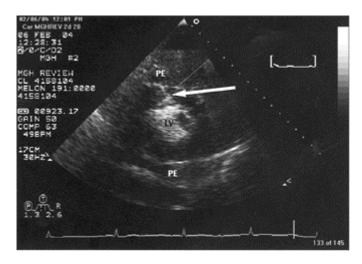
Ventricular free-wall rupture. Short-axis parasternal view of the left ventricle of an elderly woman with history of diabetes and hypertension who presented with hypotension and acute myocardial infarction after 3 days of chest pain at home. Pericardial effusion was noted on echocardiogram and intravenous contrast agent was used (filling left ventricular cavity on the figure). Arrow points to the contrast penetrating the myocardium and out to the pericardial space, indicating disruption of the anterolateral myocardial wall. Immediate surgery was performed for repair. LV: left ventricle, PE: pericardial effusion.
